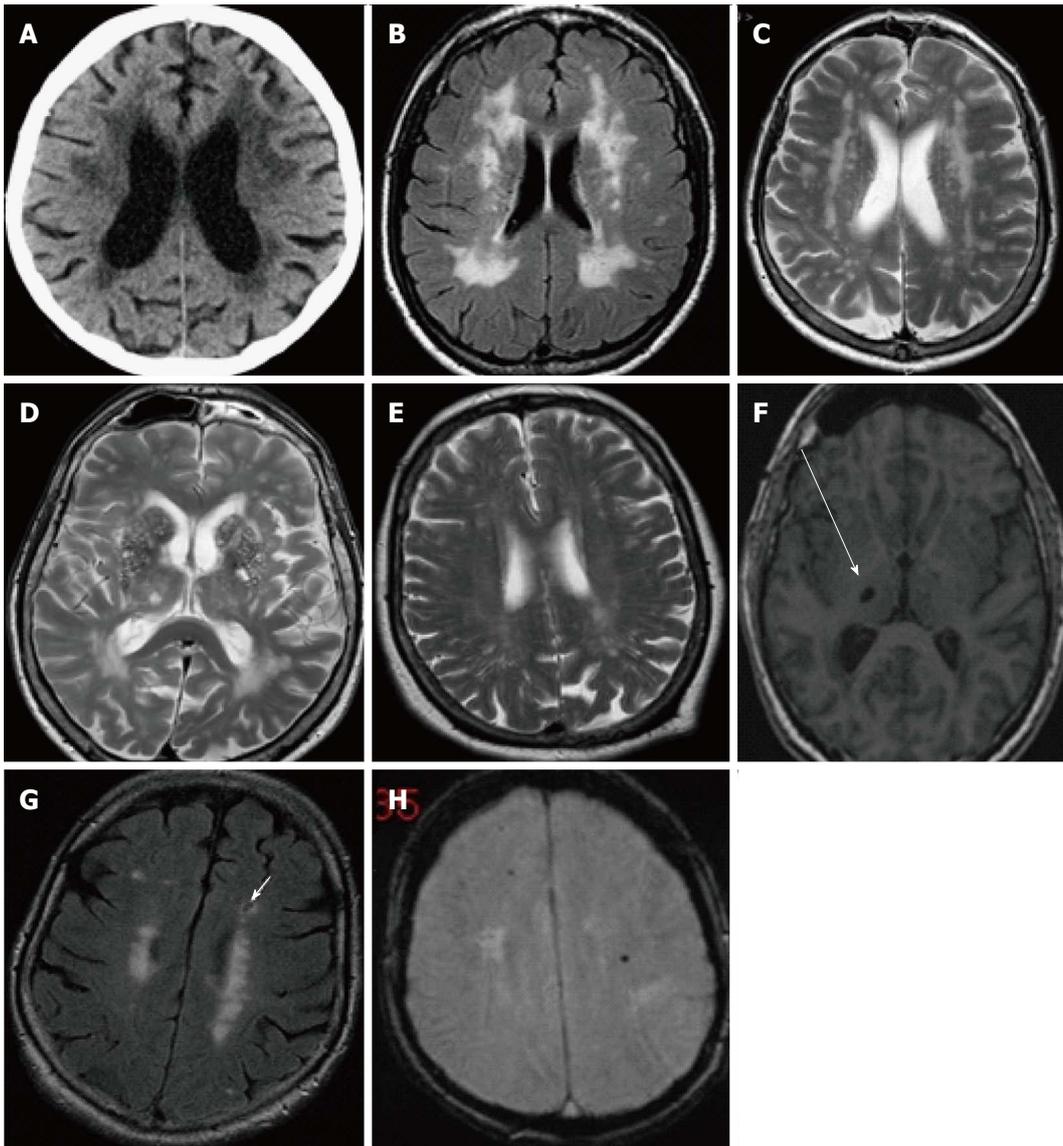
Computed tomography and magnetic resonance imaging images demonstrating structural changes secondary to cerebral small vessel disease. A: Axial image of CT brain demonstrating periventricular white matter low attenuation changes; B and C: The same seen as periventricular white matter high signal areas on FLAIR and T2 MRI; D: Prominent perivascular spaces typically seen in the basal ganglia; E: Centrum semiovale; F: Focal lacune, a cerebrospinal fluid filled space, sequelae of an old lacunar infarct in the right thalamus seen here (arrow) on an axial T1 image; G: Lacune (arrow) in the left frontal lobe on a FLAIR image, usually with a rim of high signal differentiating from a PVS; H: Cerebral microhaemorrhages, seen here as focal rounded black/low signal foci in the white matter of both frontal lobes on T2* gradient echo MRI. MRI: Magnetic resonance imaging; CT: Computed tomography.
